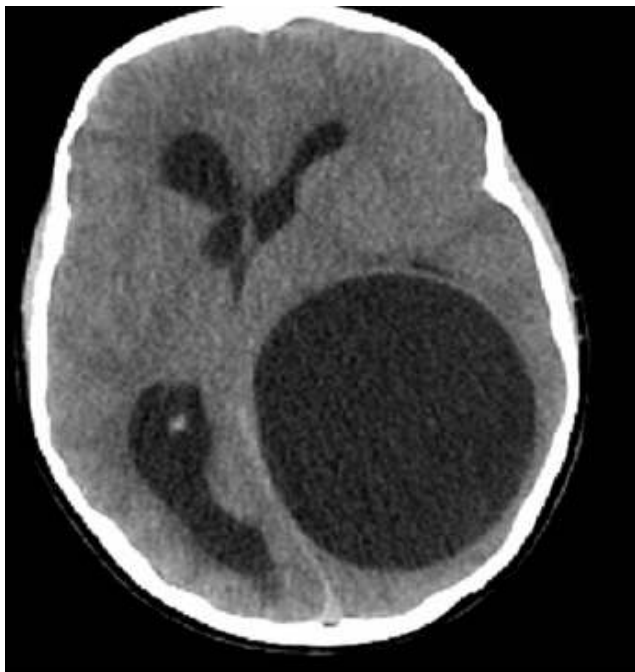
Axial cerebral CT: large left parieto-occipital mass of fluid density with intracranial hypertension and subfalcine herniation
